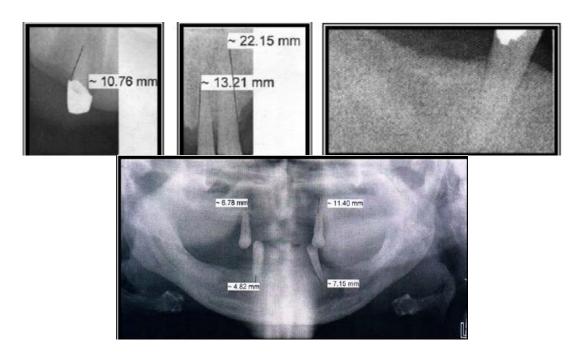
Radiographical feature of the four cases
